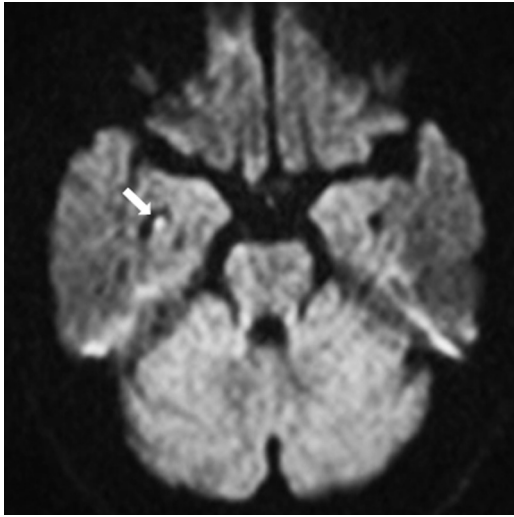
Diffusion-weighted magnetic resonance imaging scan in the axial plane shows a punctate high-signal intensity lesion in the right hippocampus (white arrow).
